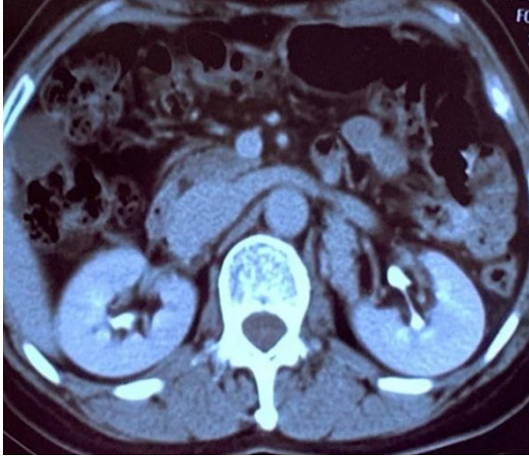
CT delay phase.
